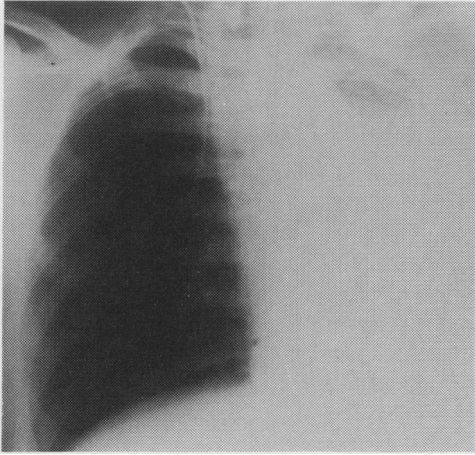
Initial chest X-ray. Note the position of the catheter is outwith the 'cannula tip positioning zone' in the right chest. The left side indicates collapse of the left base and possible effusion most likely related to aspiration in the bronchial tree.
